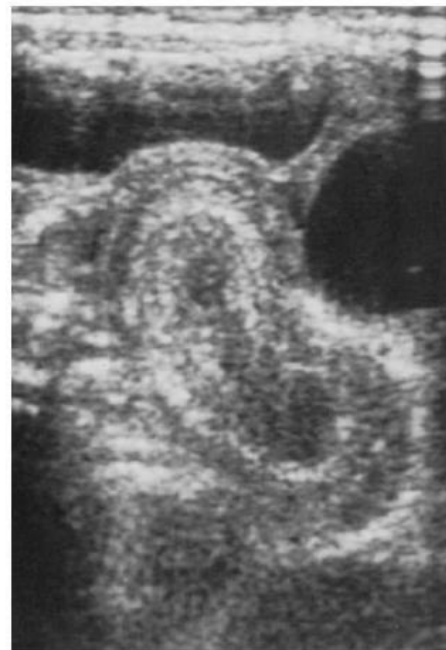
■ Sonogram showing the 'pseudokidney' sign seen with intussusception on longitudinal section.
